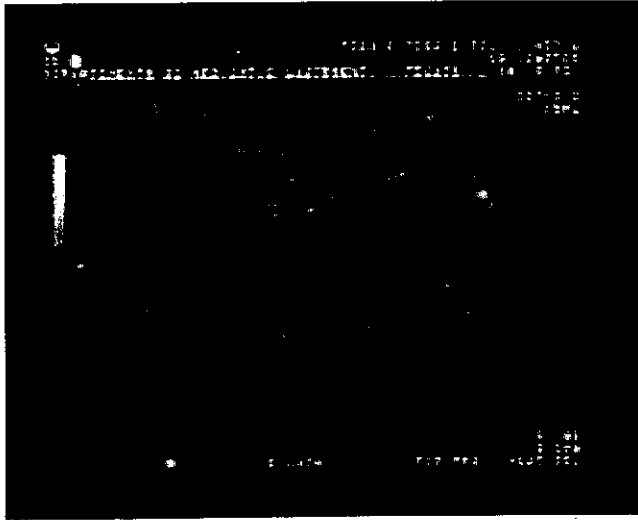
Ultrasound imaging of a floating hypoechoic thrombus localized in the superior mesenteric vein.
